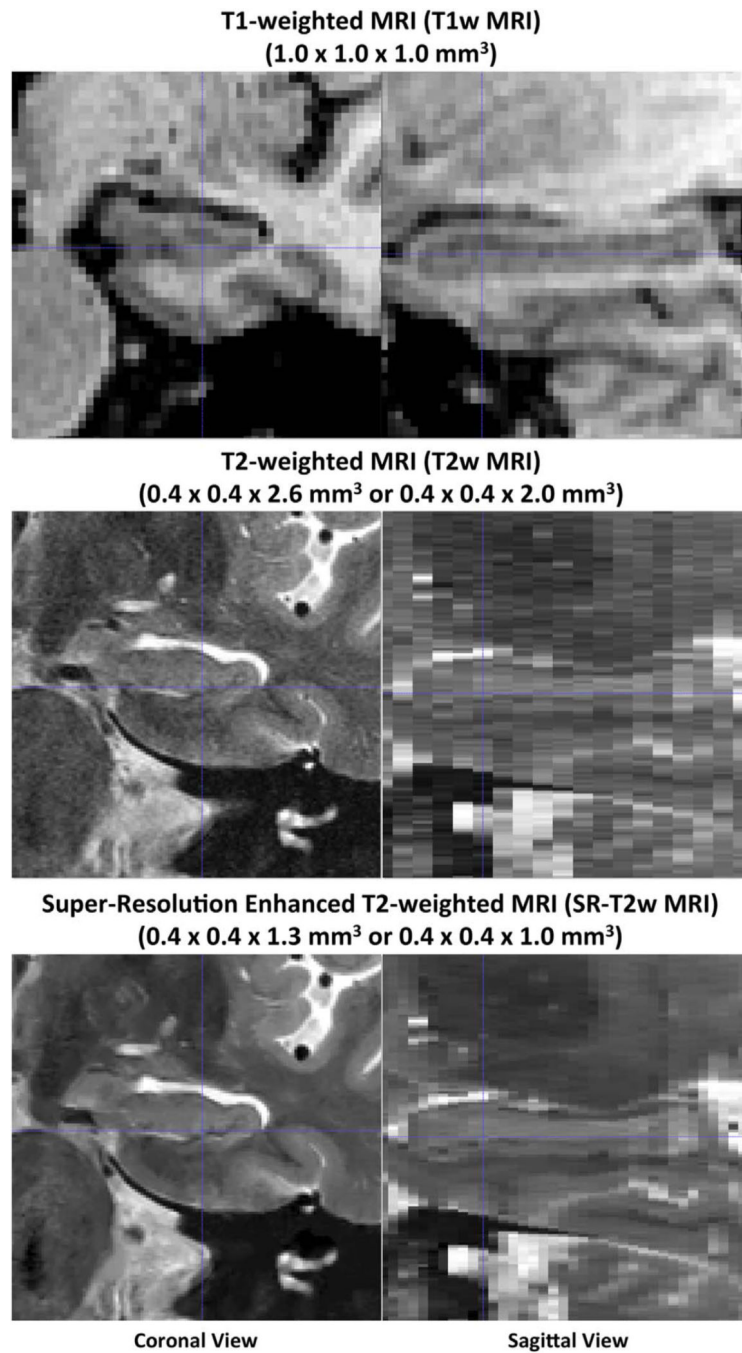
Examples of the T1-weighted MRI (T1w MRI), native resolution T2-weighted MRI (T2w MRI) and super-resolution enhanced T2w MRI (SR-T2w MRI) used in this study. The scans are from the same subject and shown in the same space.
